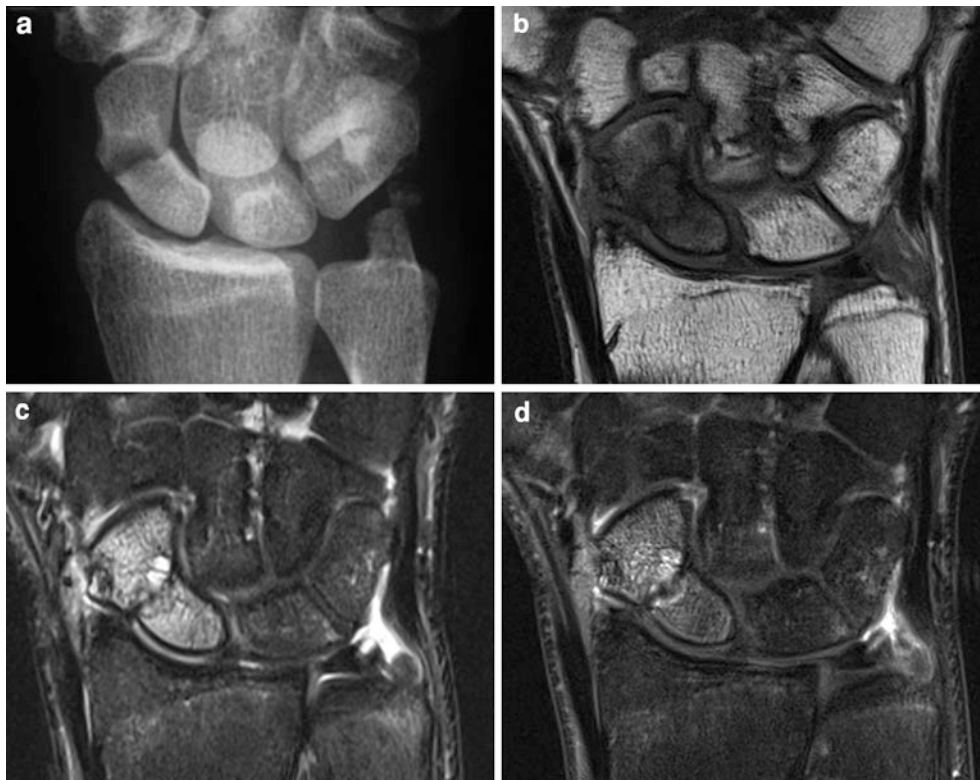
a Radiograph shows scaphoid waist fracture with cystic bone resorption 5 months after initial injury. b Coronal T1-weighted image. There is loss of normal marrow signal in the proximal pole. c STIR sequence shows diffuse high signal
